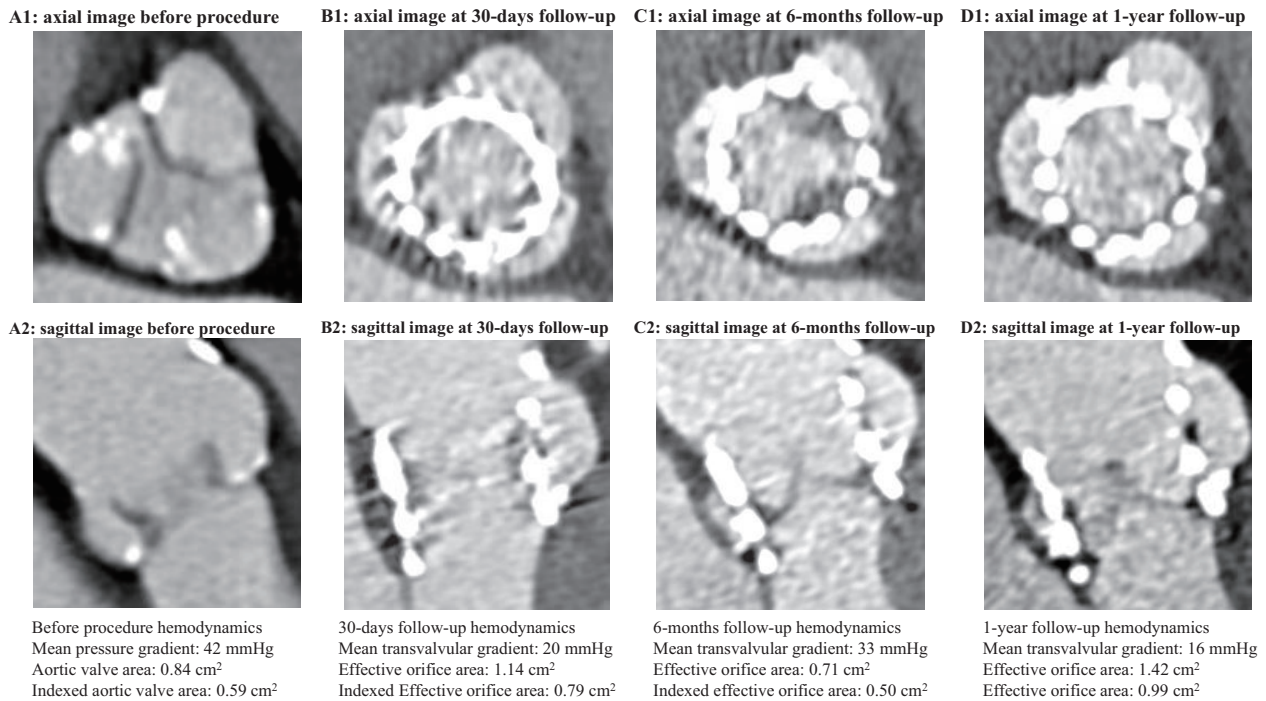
The case of a 20-mm THV with moderate HVD. Pre-procedure MDCT images of a woman in her 80s with a 20-mm THV (A1, A2). At the time of the 30-day assessment on MDCT, the HALT was not evident (B1, B2). The HALT was detected in the 20-mm THV patient with moderate HVD (C1, C2) at 6-month follow-up. The resolution of HALT and improvement in hemodynamics following 6 months initiation of anticoagulant therapy (D1, D2). HALT: hypo-attenuated leaflet thickening; HVD: hemodynamic valve deterioration; MDCT: multidetector computed tomography THV: transcatheter heart valve
